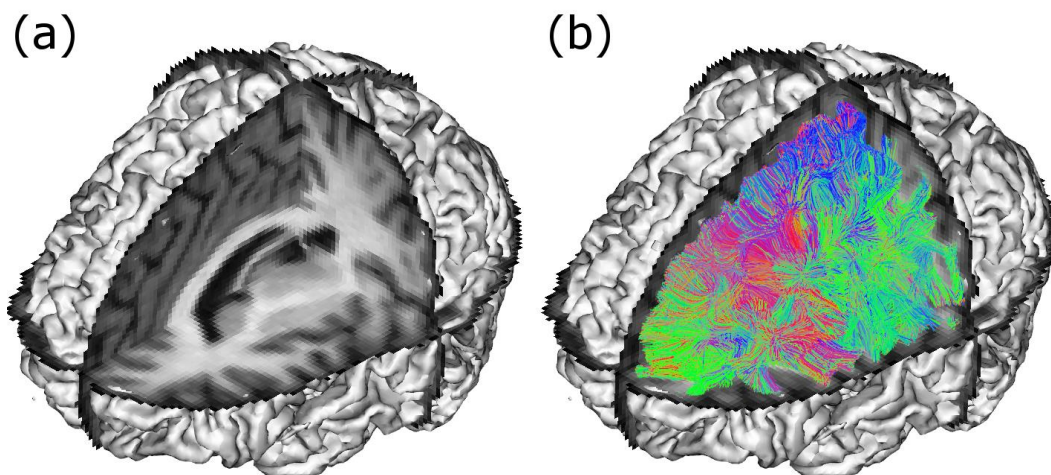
MRI images and fiber reconstruction. On the left a  $T_1$  image is shown (a). On the right the corresponding fiber reconstruction from dMRI is shown (b). Both images are visualized with an iso-surface calculated on the basis of the dMRI dataset.
